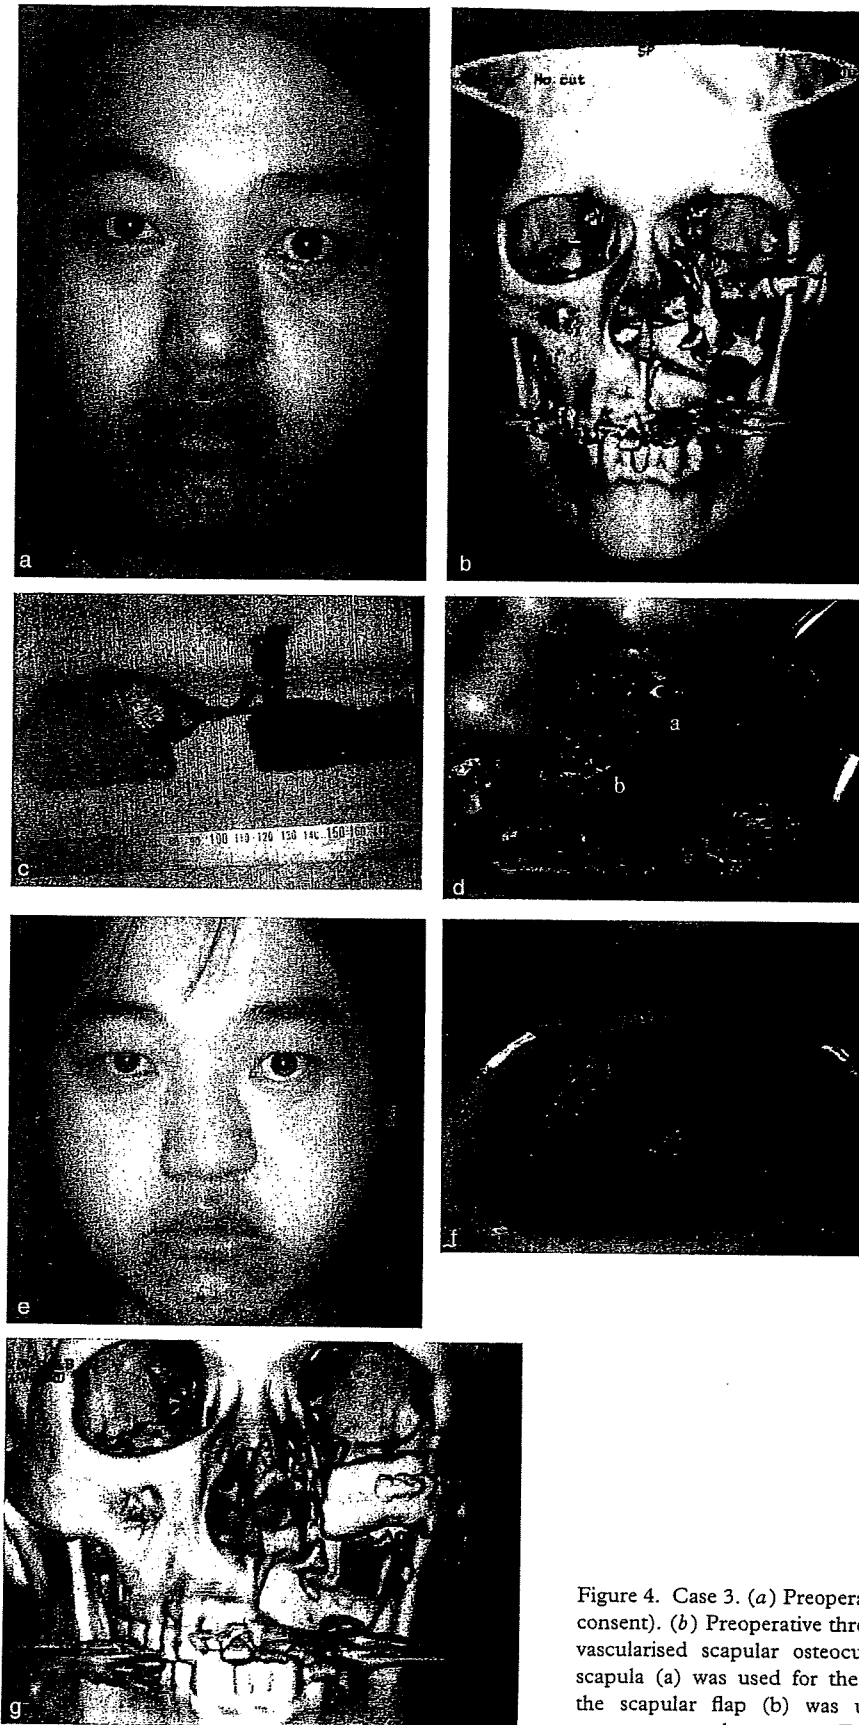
Case 3. (a) Preoperative appearance. (Published with the patient's consent). (b) Preoperative three-dimensional computed tomogram. (c) The vascularised scapular osteocutaneous flap that was harvested. (d) The scapula (a) was used for the upper horizontal plane reconstruction, and the scapular flap (b) was used for palatal closure. (e) Postoperative appearance at three years. (Published with the patient's consent). (f) The palate closed by the scapula flap. (g) Postoperative three-dimensional computed tomogram at three years.
